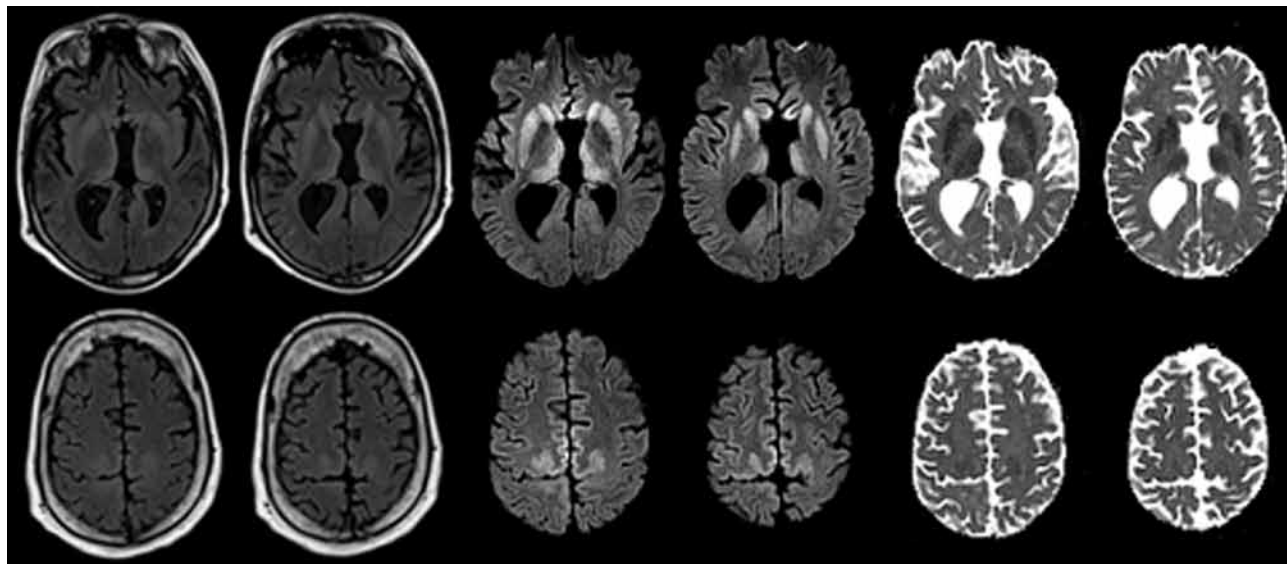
Maps showing axial fluid attenuated inversion recovery (FLAIR), diffusion-weighted imaging (DWI), and apparent diffusion coefficient (ADC) at the level of the basal nuclei (top row) and dorsal frontoparietal cortex (bottom row) of the brain of a 33.8-year-old man with agenesis of the corpus callosum, schizencephaly, and heterotopia. Note the symmetrical DWI signal hyperintensities in the striatum and dorsomedial part of the thalami. In addition, DWI signal hyperintensities occurred in the cingulate, precuneus and in the dysplastic gray matter along the anterior lips of the schizencephalic clefts at the level of the precentral gyri. The signal abnormalities are associated with decreased diffusivity on ADC maps and are much less prominent on FLAIR images. These findings are highly suggestive of Creutzfeldt-Jakob disease.
